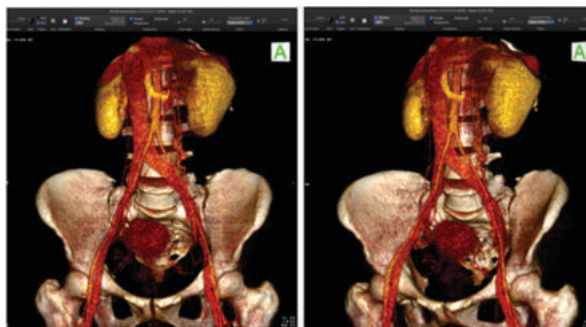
CE CT 3D reconstructed image – Showing dilated left gonadal vein along its course.
